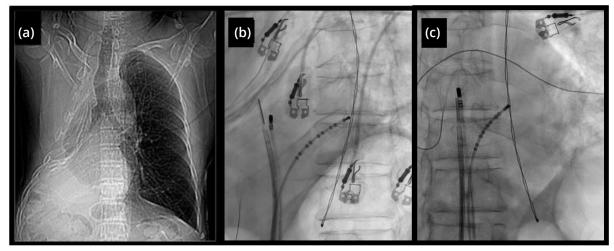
(a) Aspect of the chest X-ray after right pneumonectomy; (b, c): B: Presence of catheter in intracardiac ultrasound, catheter of ablation positioned in the region of the bundle of His; and decapolar catheter in the interior of the coronary sinus (B – left anterior oblique projection 35° and C – right anterior oblique projection 35°).
